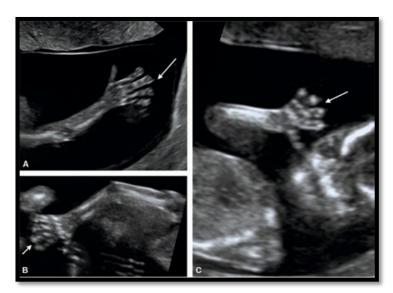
A 2 - D ultrasound of the fetal upper extremities at 13 weeks of gestation (The Fetal Skeletal System | Radiology Key, n.d.)
